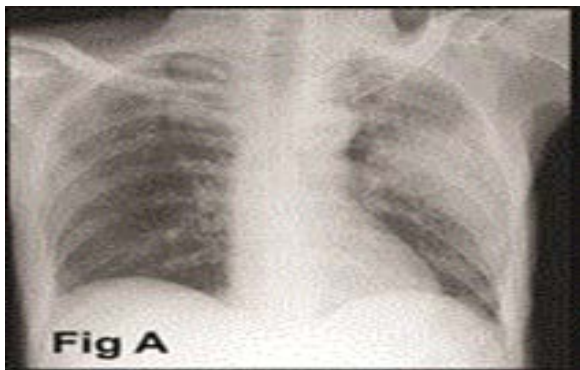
A chest x-ray showing a tumor in the left upper lobe with possibility of lateral chest wall involvement.
